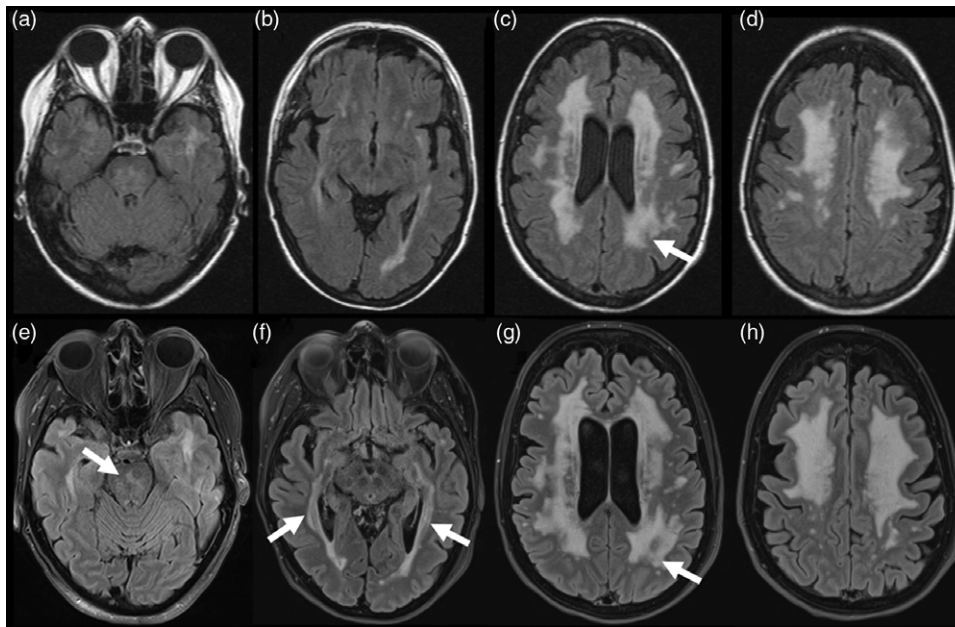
Axial T2 FLAIR images of the patient 6 years earlier at the age of 68 years (Panels A–D) and during the present evaluation at the age of 74 years (Panels E–H). Images of the patient at the age of 74 years (Panels E–H) revealed extensive confluent white matter T2 prolongation, present in the subcortical and periventricular white matter of both cerebral hemispheres including the temporal lobes (see arrows at Panel F), as well as in the brain stem (see arrow at Panel E), nonspecific in appearance and distribution but deemed most likely to represent the sequelae of severe small vessel ischemic disease. Findings were only slightly progressed compared to images obtained 6 years earlier at the age of 68 years, especially in the parietal regions (see arrows at Panels C and G). Mild interval cerebral volume loss was noted when compared to the prior examination.
